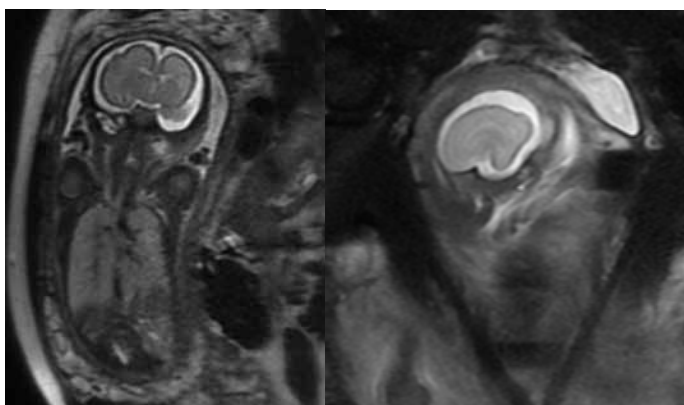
a. (left) coronal; and b. (right) sagittal images of a 27/40 gestation fetus, with an interhemispheric cyst identified at antenatal ultrasound. MRI demonstrates lack of normal sulcation. There is minimal infolding of the Sylvian fissures; the frontal cortex is abnormally smooth, in keeping with lissencephaly.
